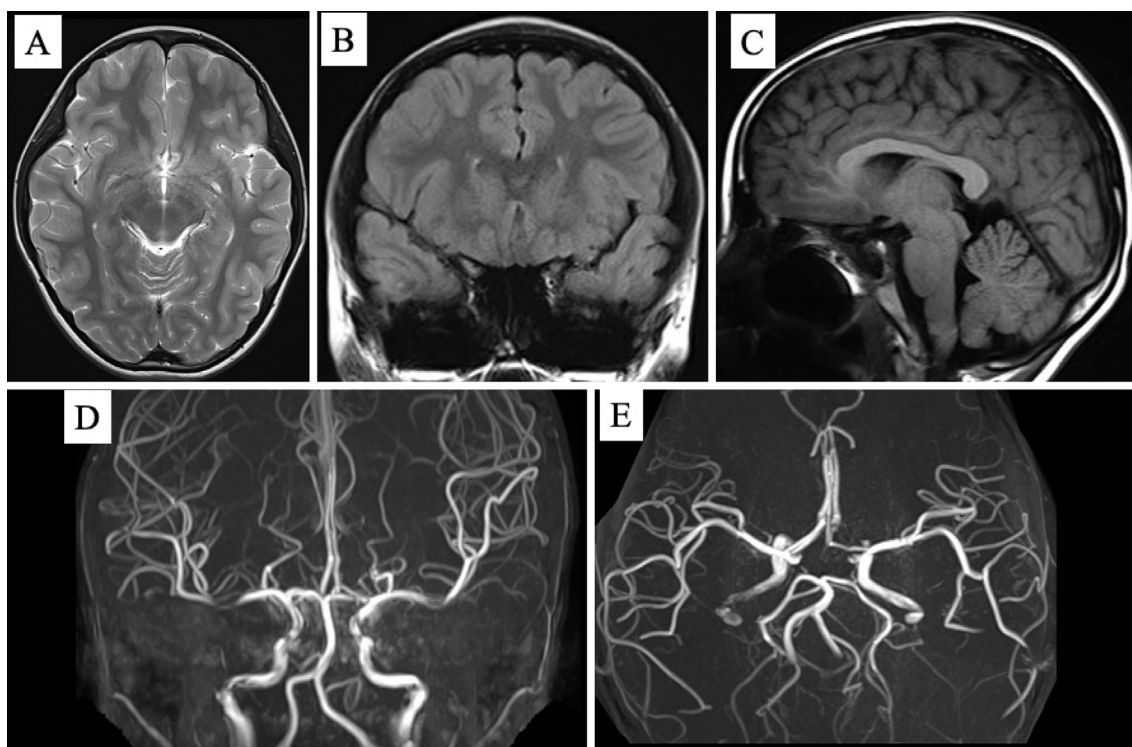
Brain magnetic resonance imaging and magnetic resonance angiography showing normal results. A: T2 sequence, axial view. B: Fluid attenuated inversion recovery sequence (FLAIR), coronal view. C: T1 sequence, sagittal view. D, E: Magnetic resonance angiography.
